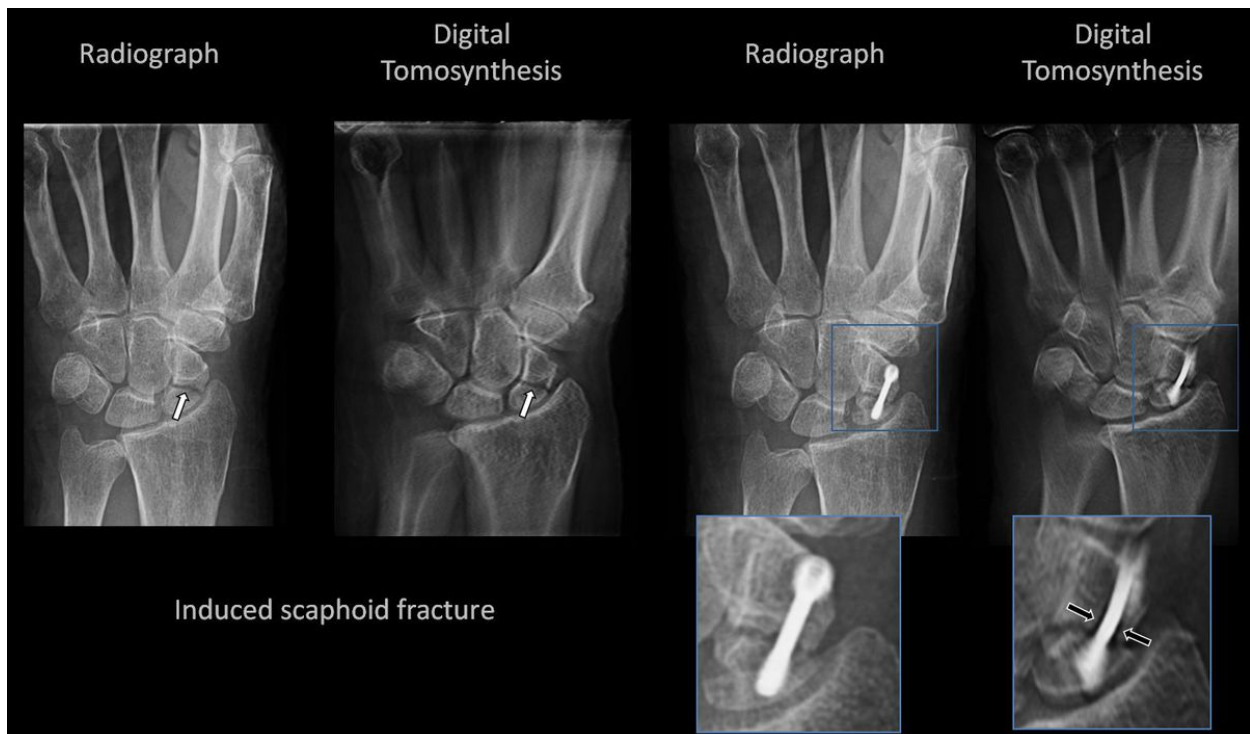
Radiograph and tomosynthesis images of scafoid fracture (left) and Herbert screw fixation (right).
